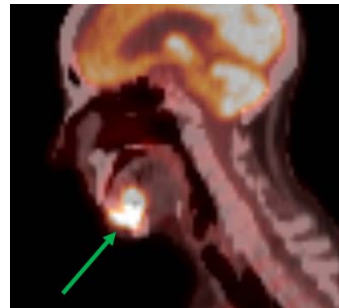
PET/CT demonstrates metabolic uptake in the tumor (green arrow). No pathologic lymph nodes were identified. Image courtesy of the University of Massachusetts Medical School, Department of Radiology.
